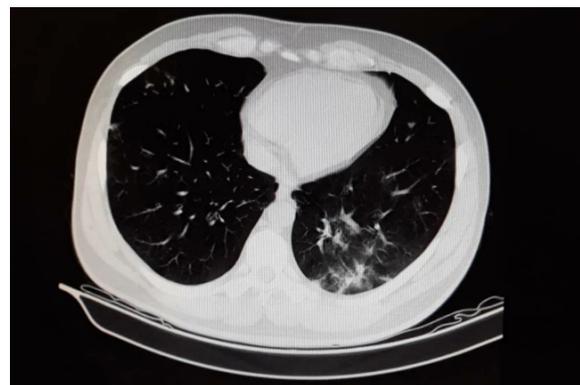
Ground-Glass Opacity (GGO), view in Lung CT-scan
